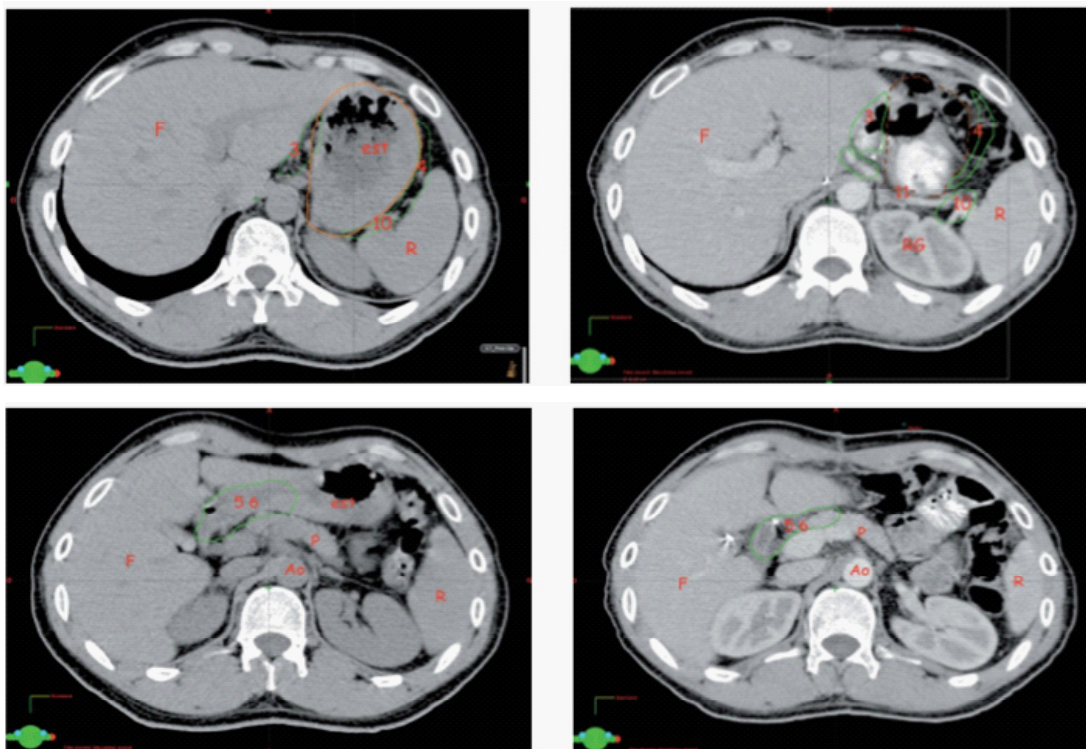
repositioning of the stomach on the postoperative CT after adjustment (brown dotted line) and identification of lymph node territories, view with representation of areas 3,4 (small and large curvature, 7 (left gastric artery) 10,11 (splenic artery and hilum) [8]
